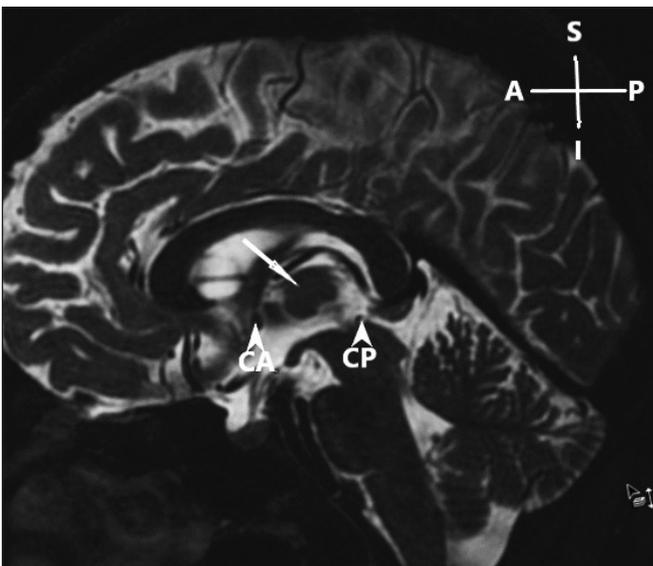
T2W MR image of left cerebral hemisphere with very large interthalamic adhesion (white arrow). CA: Anterior commissure; CP: Posterior commissure; A: Anterior; P: Posterior; S: Superior; I: Inferior.
